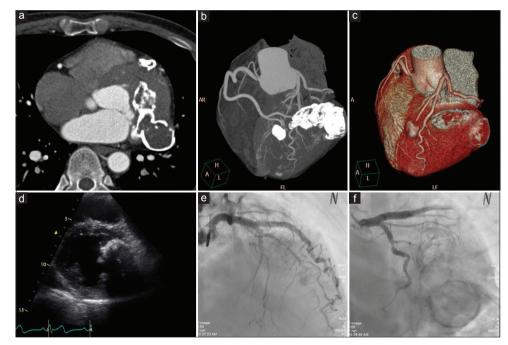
(a) Cardiac computed tomography showed huge calcified mass the lateral segments of LV and small calcified daughter mass located within the interventricular septum, extending to anterior-free wall of LV septum. (b and c) Three-dimensional reconstruction imaging showed small mass compressing the LAD artery. (d) Echocardiography revealed hyperechoic mass involving lateral LV segments. (e) Coronary angiography revealed total occlusion of LAD due to small radiopaque mass. (f) Fluoroscopy showed a huge radiopaque mass in the LV. LV: Left ventricle; LAD: Left anterior descending.
